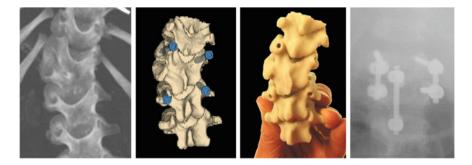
Pre-operative thick maximum intensity projection CT of patient with thorocolumbar congenital scoliosis, rendering of 3D templating results developed with the spine surgery planning tools, the physical model printed from the plan, and the post-operative radiograph
